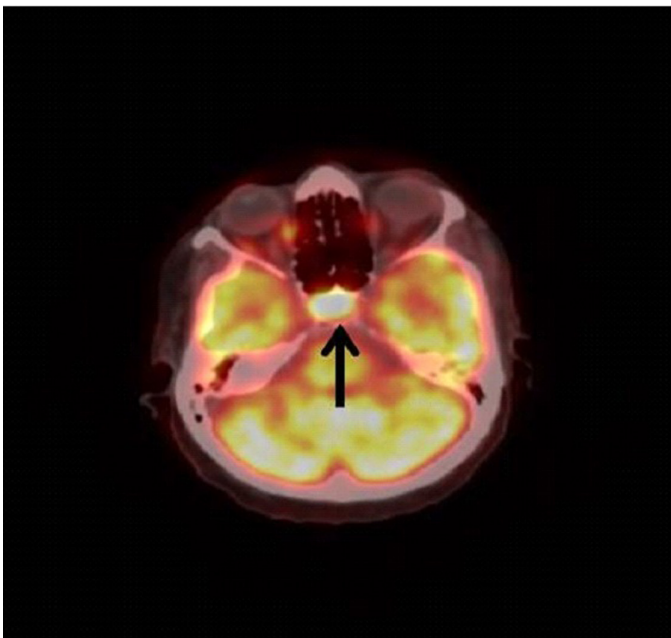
Increased 18F-FDG uptake in seller region. 18F-FDG, 18F-fluorodeoxyglucose.
